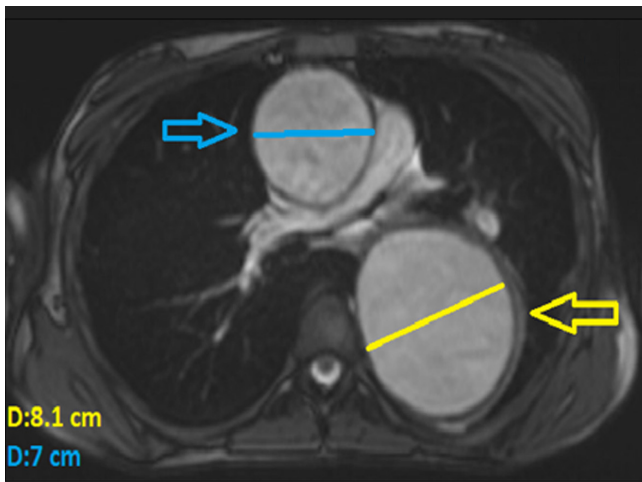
Axial view of cardiac magnetic resonance imaging, showing a massively dilated ascending aorta (blue arrow, 7 cm in diameter) and a large-sized descending aorta aneurysm (yellow arrow, 8.1 cm in diameter)
